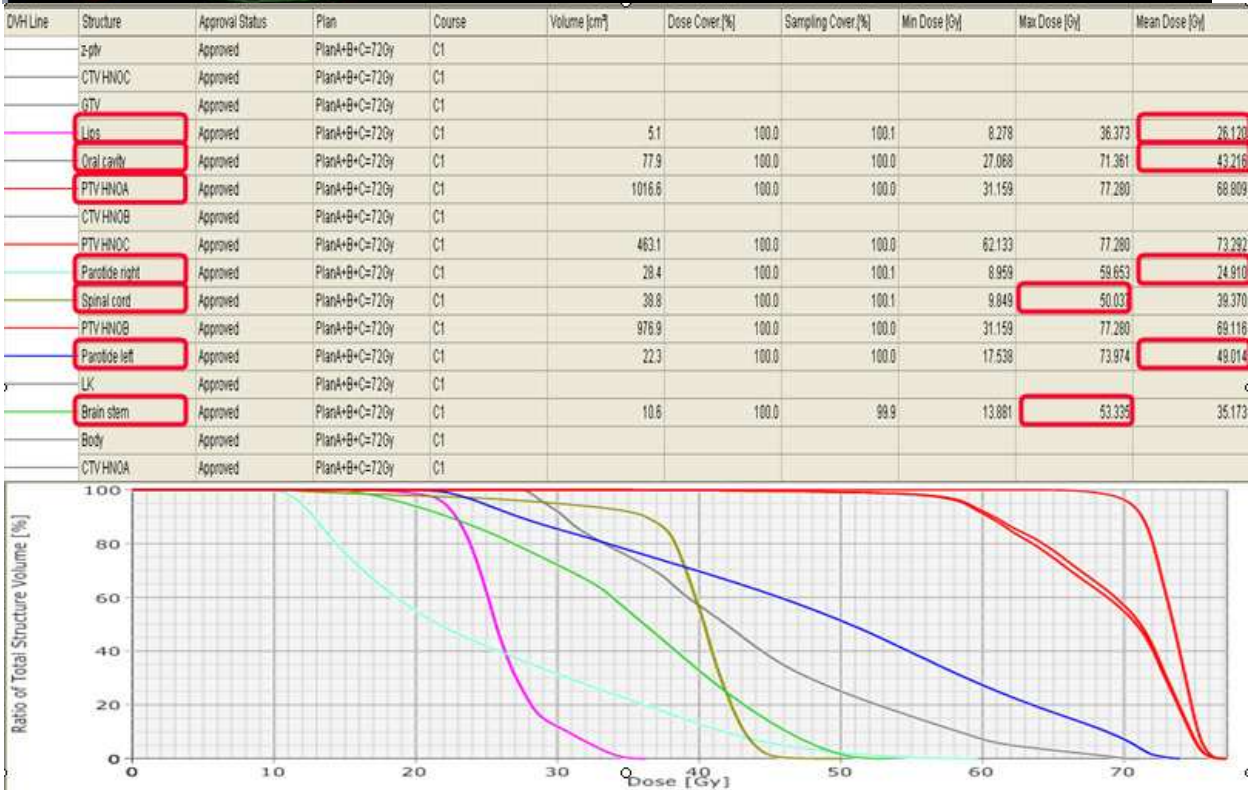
SEQ-IMRT plan for first phase treatment using 9 coplanar fields with 6-MV x-rays: First plan included PTV A (low-risk), PTV B (high-risk), and PTV C (gross tumor): 30 Gy (2 Gy/fraction) + 19.6 Gy (2x1.4 Gy/fraction) to a total dose of 49.6 Gy, followed by second plan included PTV B (high-risk), and PTV C (gross tumor): 9.8 Gy (2x1.4 Gy/fraction) to a total dose of 59.4 Gy, followed by third plan included PTV C (gross tumor): 19.8 Gy (2x1.4 Gy/fraction) to a total dose of 72 Gy. (a) Dose colour wash analysis displayed in axial, coronal, and sagittal images. (b) Absolute and relative DVH from the summation plan showed dose received by target volumes and different OARs (contralateral right parotid gland received D_{mean} 24.9 Gy).
